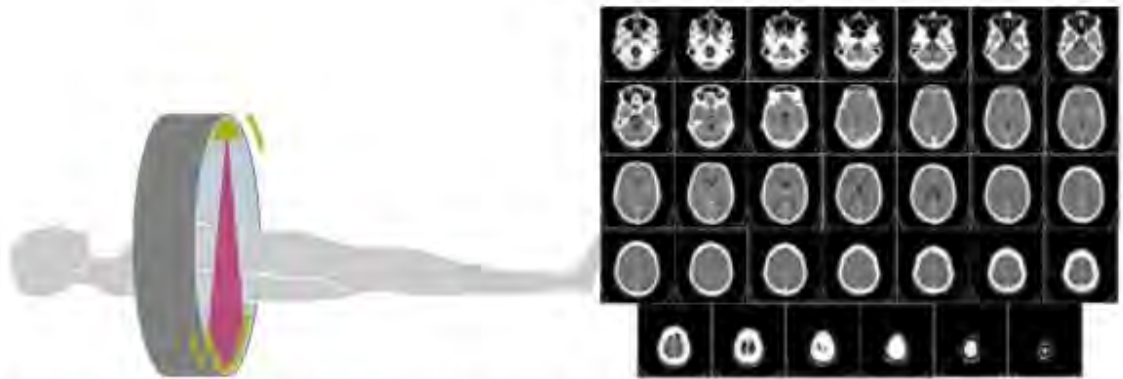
Computed tomography of human brain, from base of the skull top. Taken with intravenous contrast medium [Curtsy of CT Head Anatomy and Pathology, Jeanette Dadds BHH Louise Bishop GHH Shirley Atkinson SHH CT Clinical Co-ordinators, APRIL 2011]
